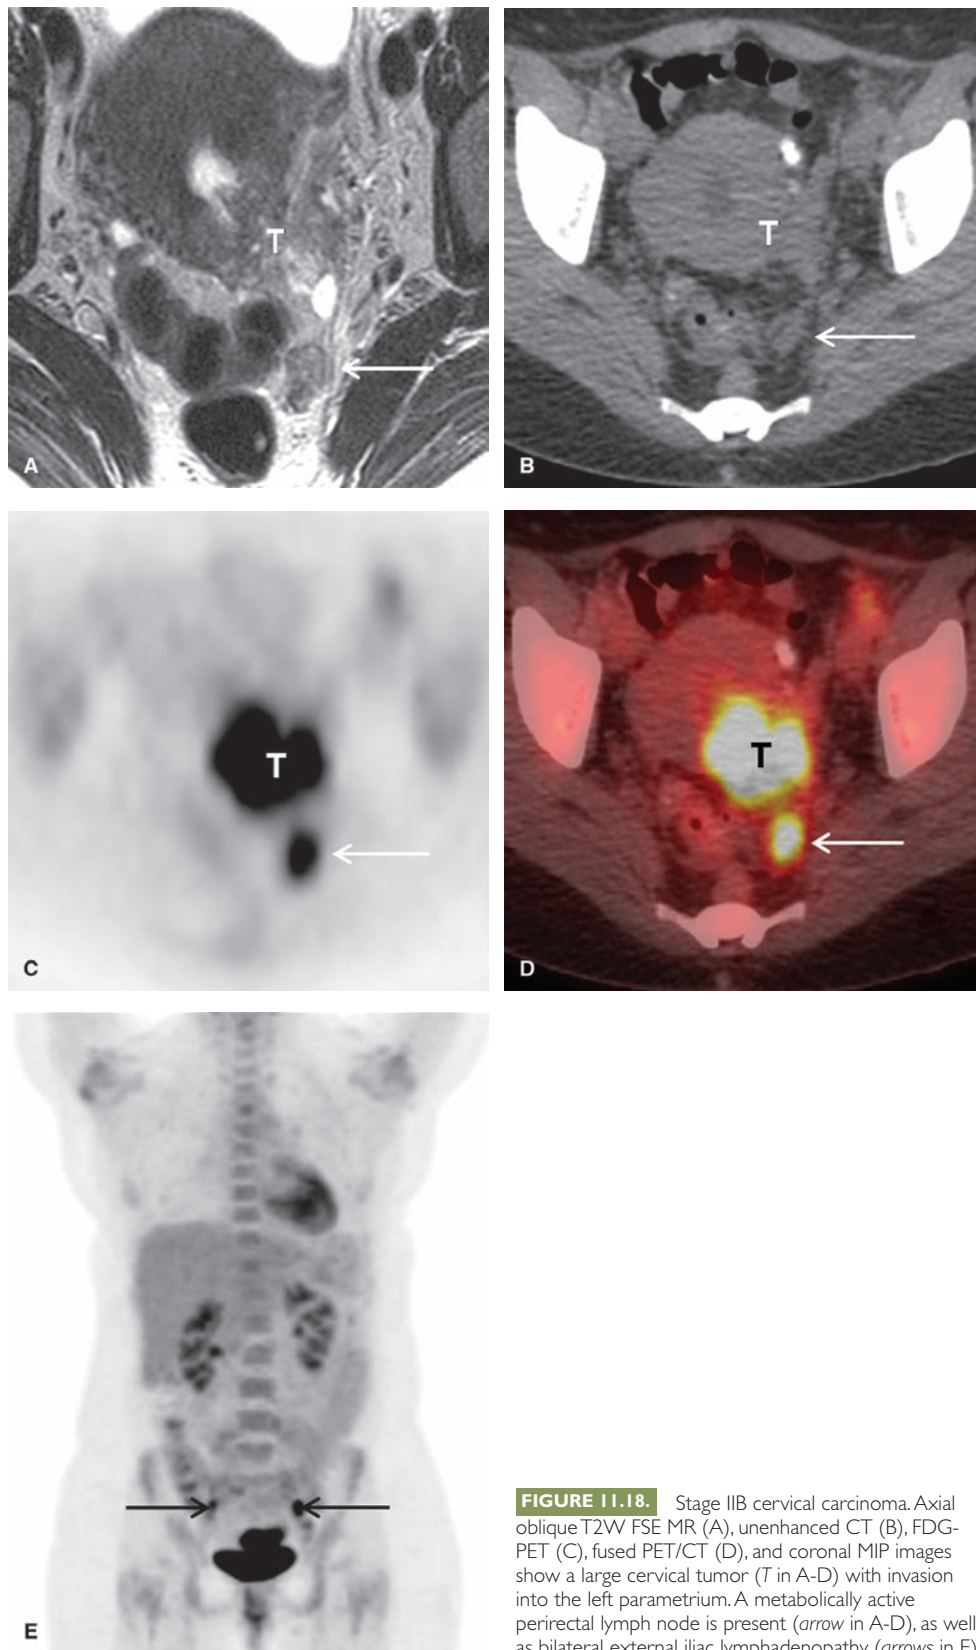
Stage IIB cervical carcinoma. Axial oblique T2W FSE MR (A), unenhanced CT (B), FDG-PET (C), fused PET/CT (D), and coronal MIP images show a large cervical tumor (*T* in A-D) with invasion into the left parametrium. A metabolically active perirectal lymph node is present (*arrow* in A-D), as well as bilateral external iliac lymphadenopathy (*arrows* in E).
